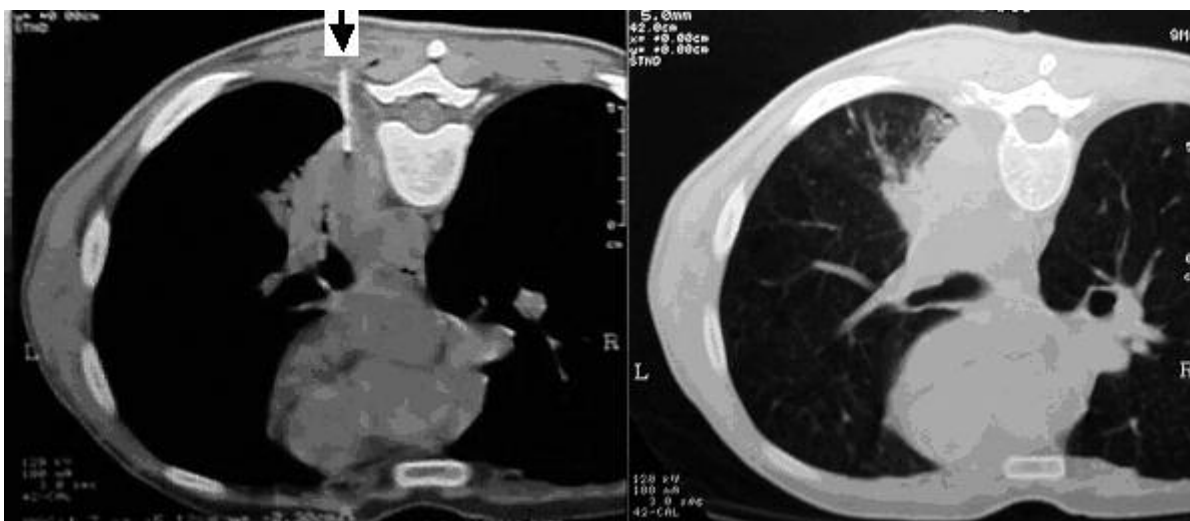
CT scanning during fine needle aspiration biopsy. Arrow points out the needle into the mass.
